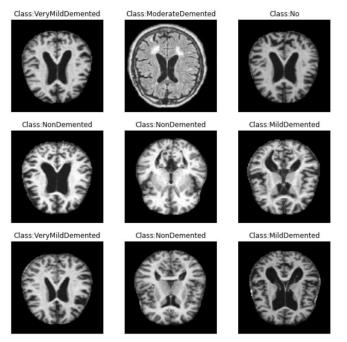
Various brain MRI scans
